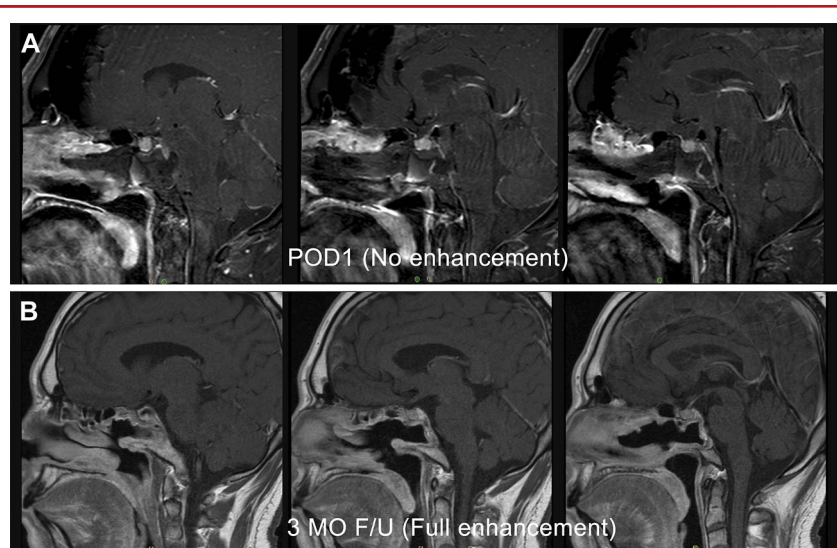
A. Early postoperative sagittal T1-weighted image postcontrast with fat suppression shows a C-shaped flap underlying the operative defect with no enhancement of the flap. B. 3-month follow-up MR imaging of sagittal T1-weighted postcontrast shows robust and thicker enhancement of the flap. POD 1, postoperative day 1.
